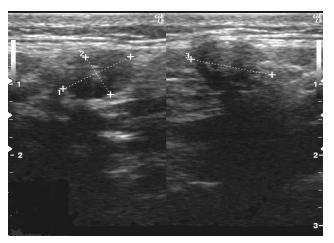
Ultrasonography of the cyst.
